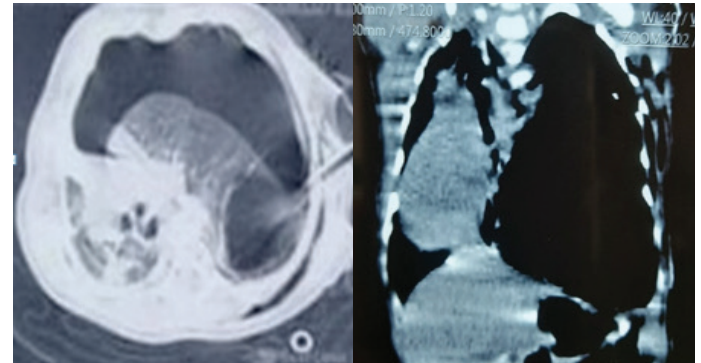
Axial and Coronal section on CT chest showing cystic lesion in left lower lobe with significant contralateral mediastinal shift, herniation of ipsilateral lung with hypoplasia of contralateral lung along with iatrogenic left-sided pneumothorax and subcutaneous emphysema. The tip of the chest tube drain is seen within the cyst.
